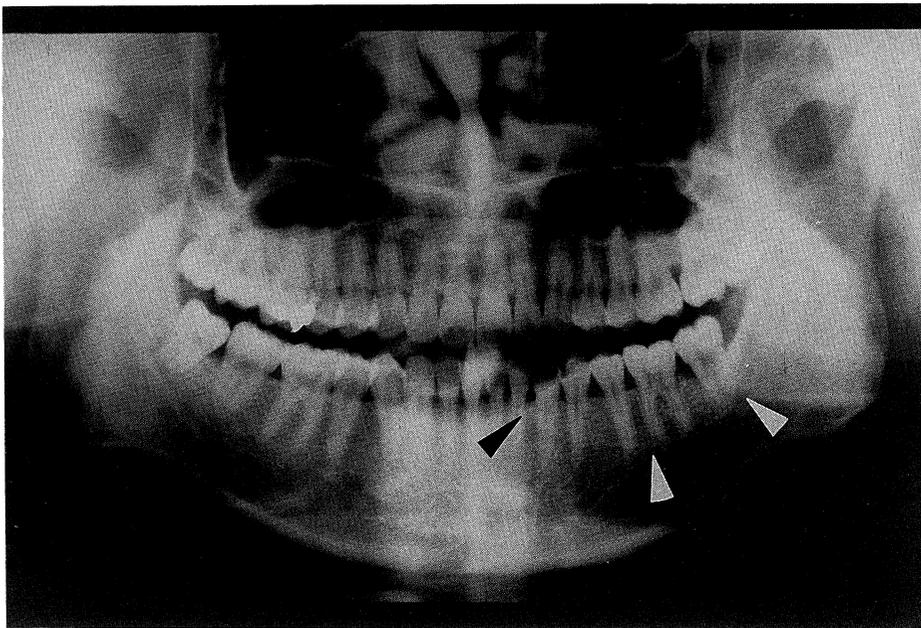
Panoramic radiograph showing an ovoid lesion overlying the left premolars and the molars of the mandible.
